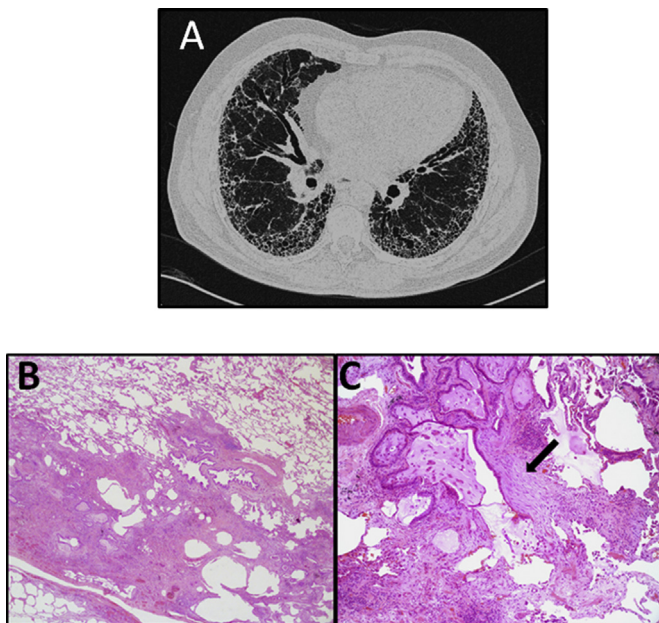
Hallmarks of usual interstitial pneumonia A) High-resolution computed tomography showing architectural distortion with subpleural and basal reticulation, traction bronchiectasis, and honeycombing. B) and C) Pathology of UIP pattern. B) Extensive subpleural fibrosis alternating with areas of mild fibrosis and others of uninvolved parenchyma in an appearance named “patchwork pattern”. C) High magnification of an UIP lung showing architectural distortion by honeycombing and an area of active fibrosing process identified by a large subepithelial fibroblastic focus (arrow).
